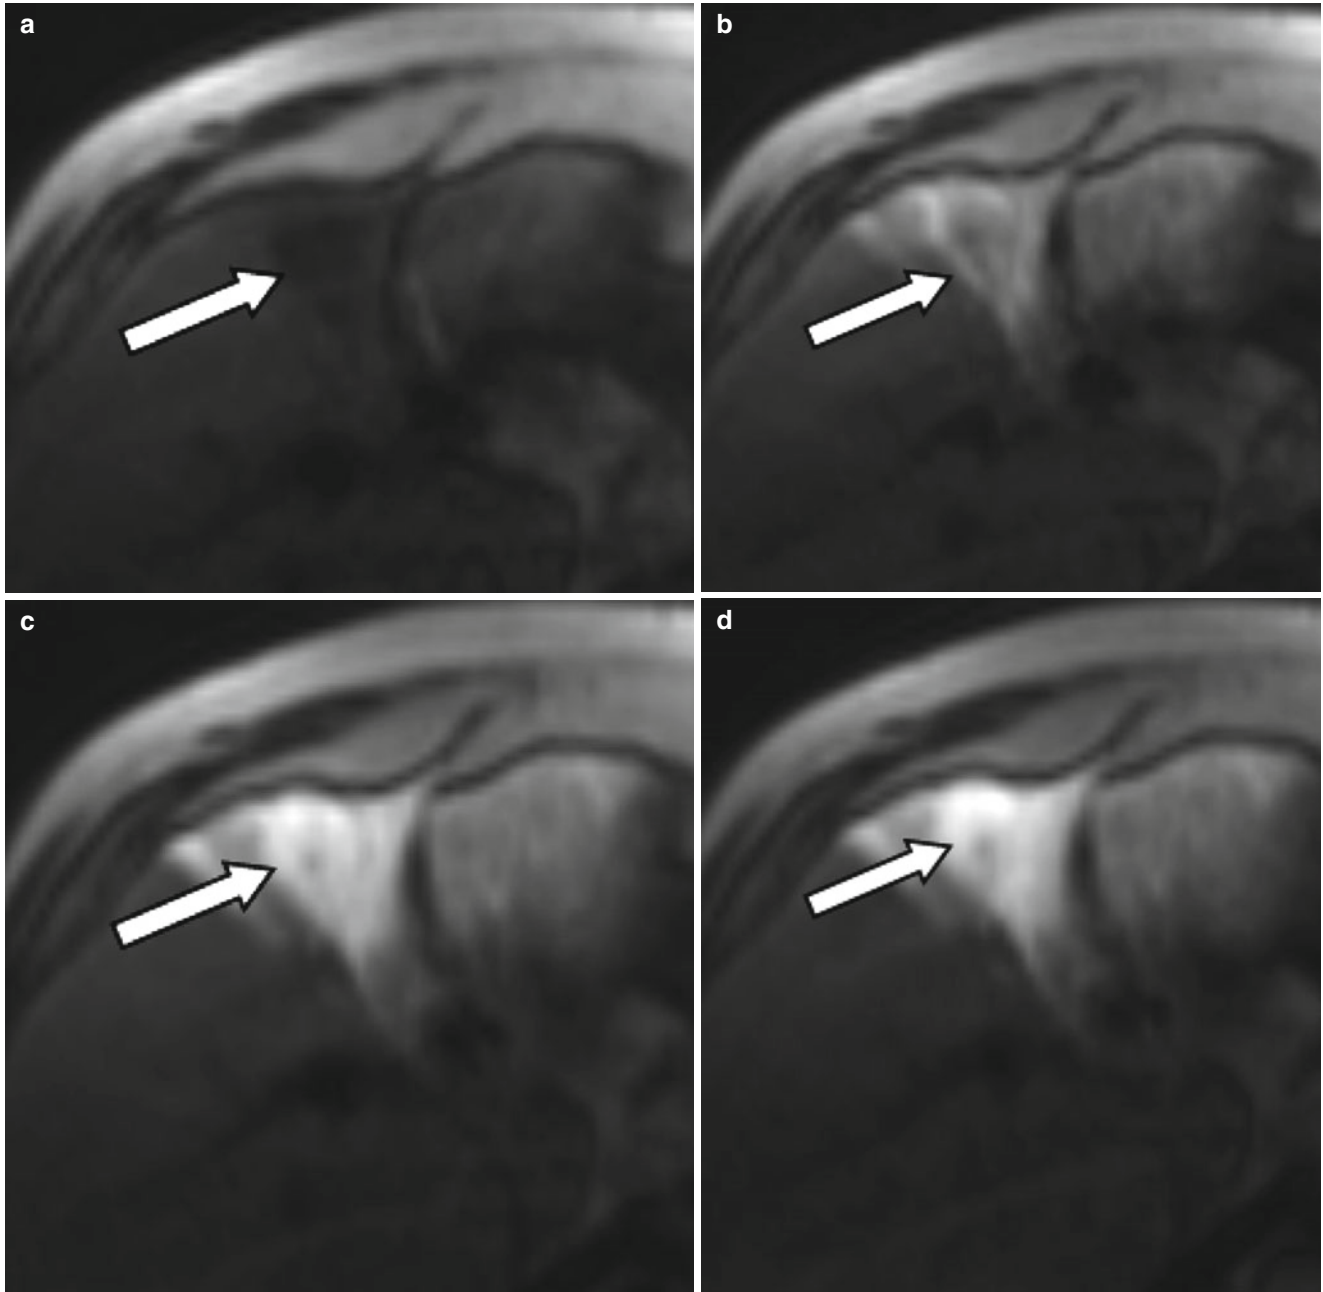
A 54-year-old male patient with an HCC lesion involving segment 4b of the liver (*arrow*) for treatment with radioembolization. After selective catheterization of the right hepatic artery, patient was transferred to the MR suit to obtain TRIP MRI images before treatment. Serial dynamic MRI images were obtained by administration of contrast agent through intra-arterial catheter (a–f) confirming the therapeutic site
